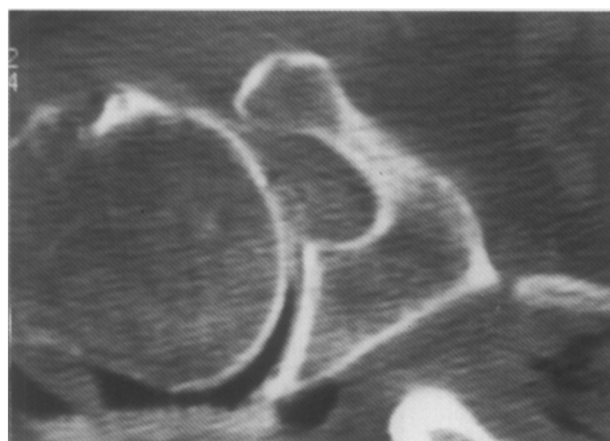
CT scan of impingement on humeral head by coracoid. Impingement was caused by anterosuperior migration of humeral head that was caused, in turn, by massive rotator cuff tear. Distance between bones was 2 mm on CT scan.
